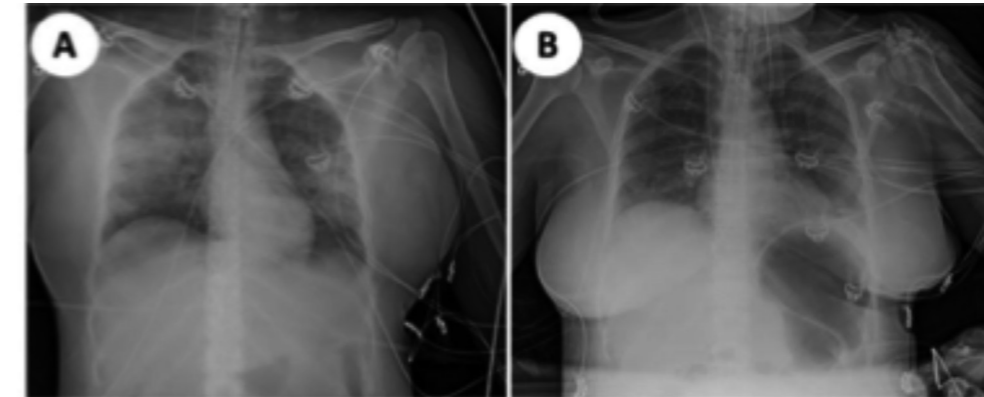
Radiographic chest image after the procedure (A) shows increased consolidations in both lung fields. After one week (B) the densities were cleared.
